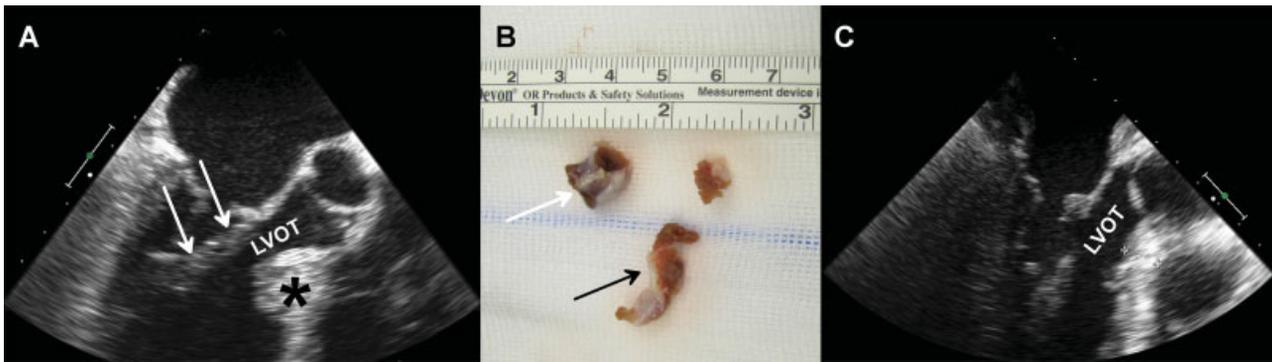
Transesophageal echocardiography B-mode views showing (A) preoperative septal hypertrophy (black asterisk) and a thick chord (white arrows) attached to the anterior mitral leaflet and the anterolateral papillary muscle, and (C) the postoperative result without left ventricular outflow tract (LVOT) obstruction. Measured septal wall thickness in (C) = 12 mm. (B) Image of the resected muscular chord (black arrow) and the resected segment of the hypertrophic septum (white arrow). Top scale on the bar measures centimeters.
